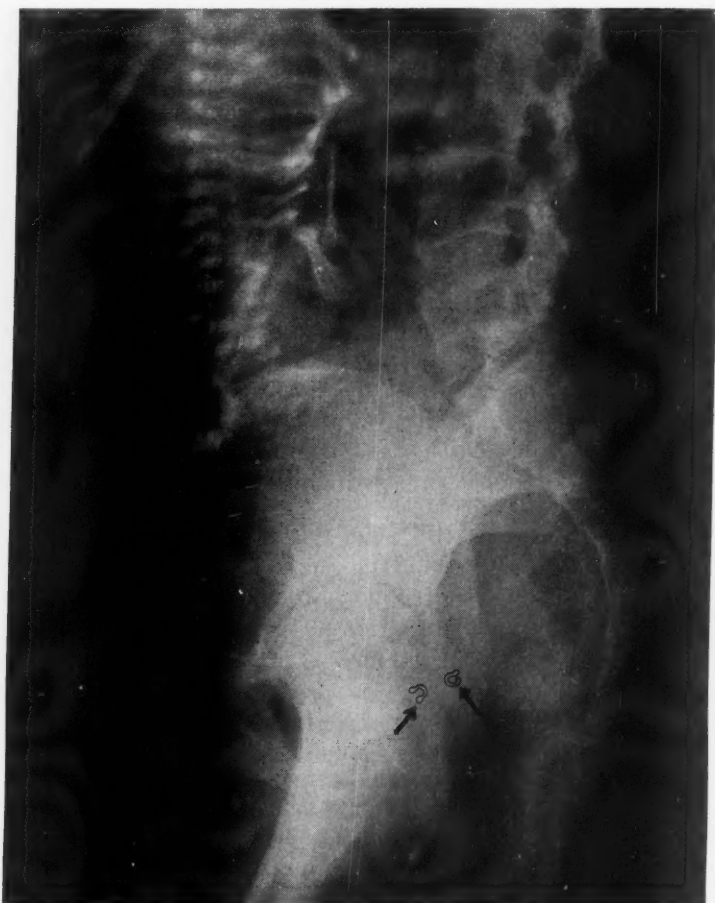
Lateral x-ray, metal clips on cervix. Early first stage of labor.
